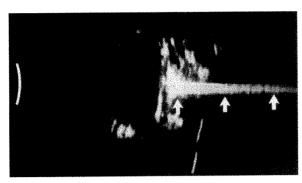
(Whitacre). B-scan ultrasonogram of an eyebank eye that had 0.2 ml of air injected intravitreously, forming multiple small bubbles. A comet tail artifact (arrows) was produced. The eye is horizontal and the probe was in line with the visual axis.
